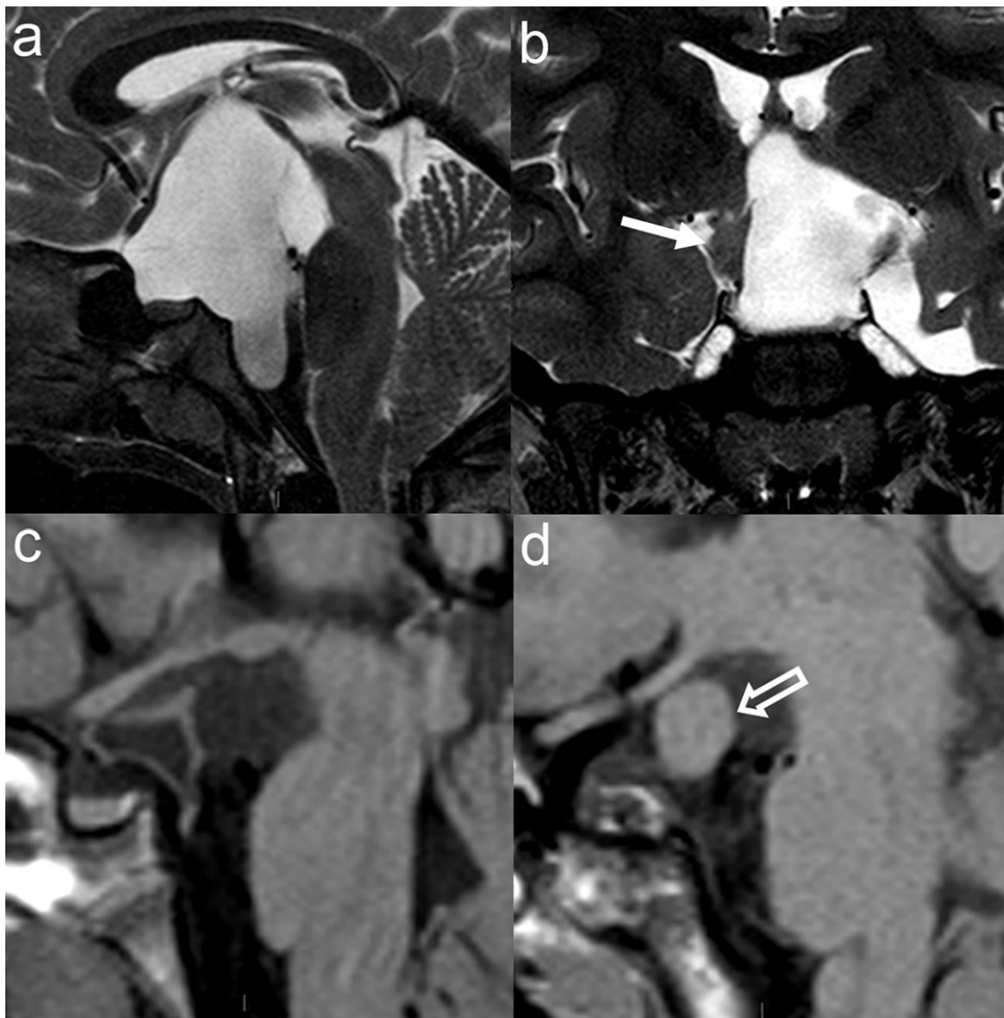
Coexistent suprasellar arachnoid cyst and hypothalamic hamartoma in a 8-year-old boy with precocious puberty. (A) Sagittal T2-weighted image; (B) Coronal T2-weighted image; (C, D) Sagittal T1-weighted images. (A, B) Brain MRI at admission shows a huge suprasellar arachnoid cyst. Along the right wall of the cyst a solid mass, isointense to brain parenchyma, is demonstrated (*arrow*, B). (C, D) Brain MRI performed following surgical fenestration of the cyst better shows the peduncolated hamartoma, projecting into the interpeduncular fossa (*open arrow*, D).
